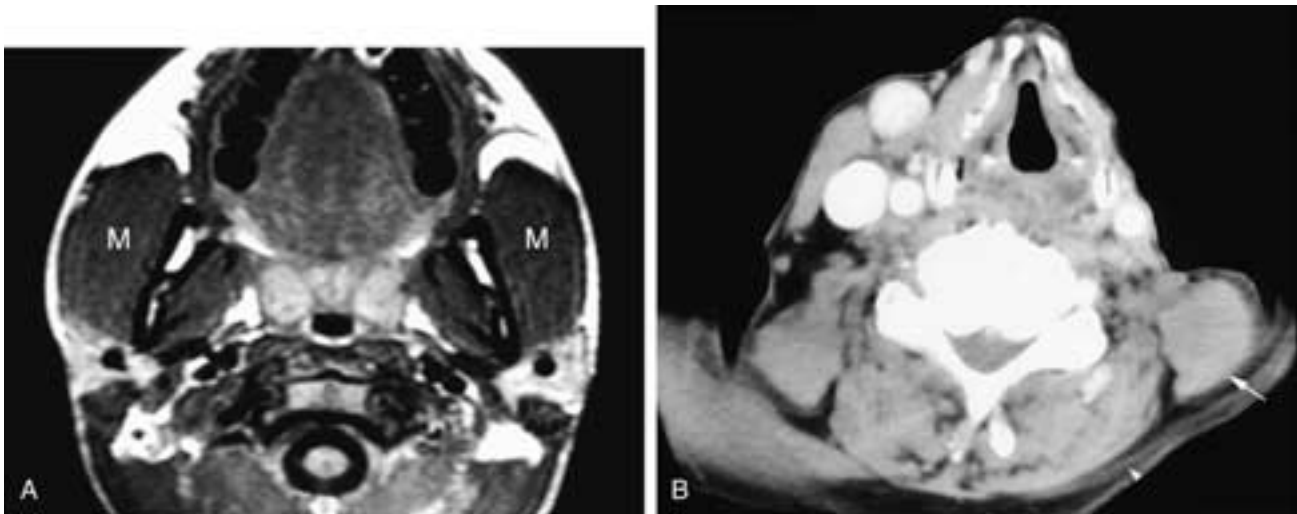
Axial T1-weighted MR image (A) shows bilateral enlargement of the masseter muscles (*M*) in this patient with masseteric hypertrophy. In B, an axial contrast-enhanced CT scan on a patient who has had a left radical neck dissection shows atrophy of the left trapezius muscle (*arrowhead*). There is early hypertrophic enlargement of the left levator scapulae muscle (*arrow*).
